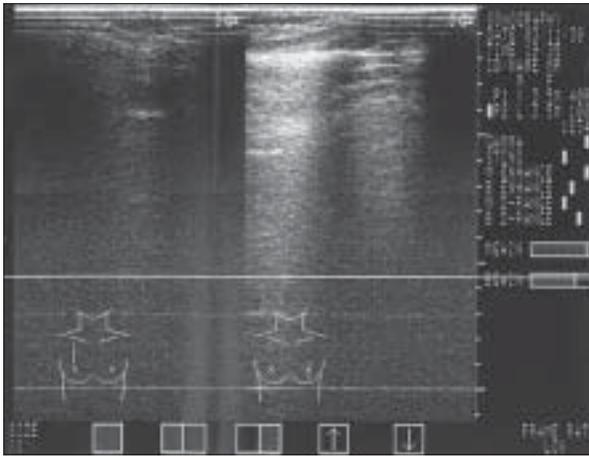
Breast sonography of the patient who received 1 mg/day finasteride
